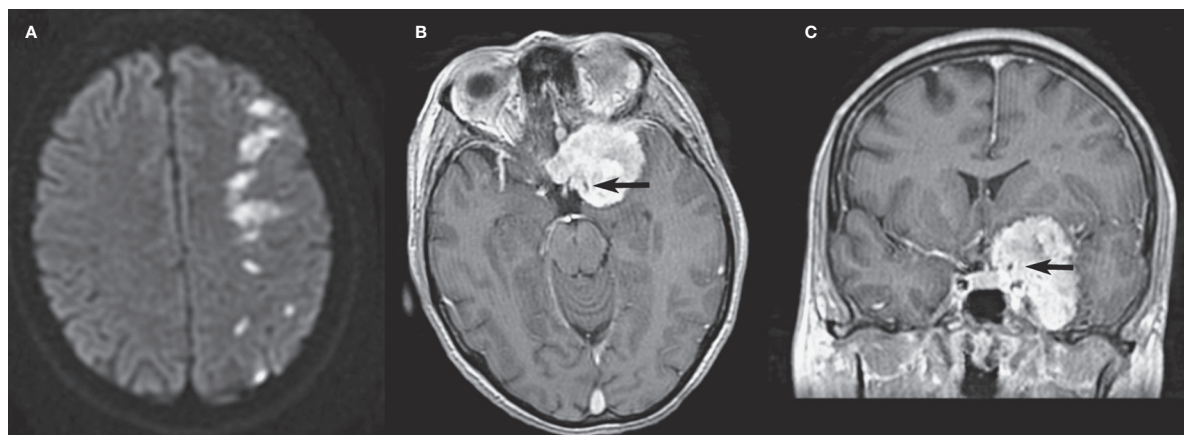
MRI at presentation. A) Axial diffusion-weighted image showing multiple hyperintense signals consistent with ischemia of the junction of middle cerebral artery (MCA) and anterior cerebral artery territories. B,C) Preoperative T1-weighted images after gadolinium injection in axial (B) and coronal (C) planes showing the sphenoid meningioma encasing the supraclinoid portion of the internal carotid artery (arrow) and the MCA.
